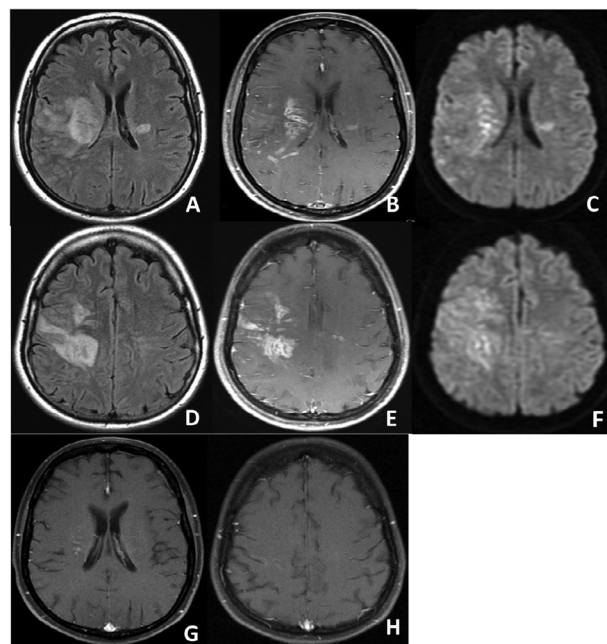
MRI brain of the second patient showed the area of vasogenic brain edema at right frontal lobe and corona radiata on FLAIR (A, D) with multiple tract-like enhancement after contrast administration (B, E). Central restricted diffusion within these lesions is seen on DWI (C, F). At the end of treatment, the follow-up MRI brain demonstrated marked improvement of the enhanced lesions in the right corona radiata (G) and the right frontal lobe (H) on T1W with gadolinium
